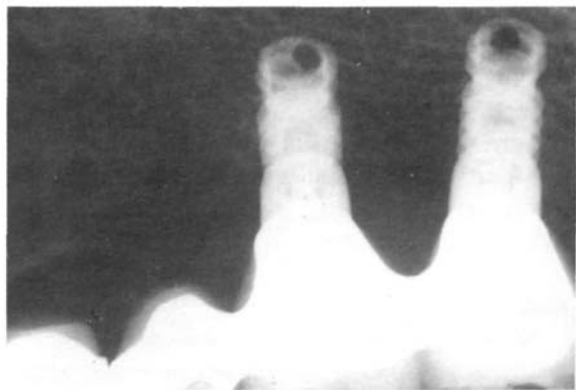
Peri-implant zone radiograph two years later for another patient in the mandible. It did not show any abnormal change or radiolucency.
